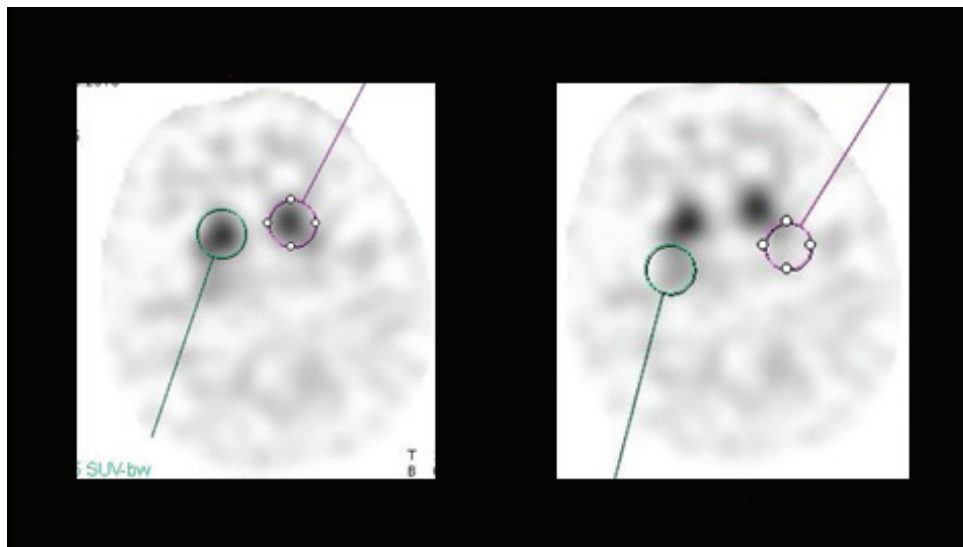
Bilateral caudate and putaminal SUV_{max} and SUV_{peak} values calculated using xSPECT Quant using ^{123}I -Ioflupane (DaTscan) in a patient with Parkinson's disease. Caudate SUV_{max} is 7.75 and Putaminal SUV_{max} is 4.12 on the left side with putamen/caudate ratio of 0.53. This is in sharp contrast to the SUV_{max} and ratio estimations in the normal patient (Figure 17: caudate SUV_{max} of 11.37, putamen SUV_{max} of 9.84, putamen/caudate ratio of 0.93).
